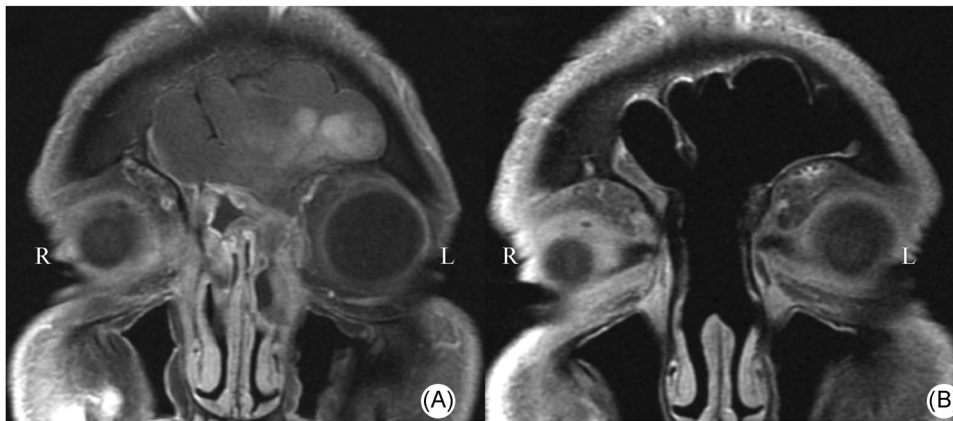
Preoperative (A) magnetic resonance imaging (MRI) of a patient with significant frontal sinus obstruction, demonstrating significant frontal sinus disease. Postoperative (B) MRI of the same patient after the Draf III procedure. Note the removal of intersinus septum and superior nasal septum creating a large common cavity for sinus drainage (Property of Columbia University Division of Rhinology)
